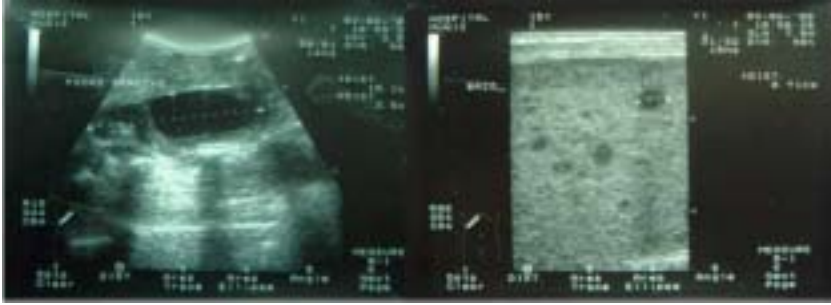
Abdominal ultrasonography showing a psoas muscle abscess and multiple hypo-echoic lesions in spleen, suggestive of TB microabscesses in the same patient as in Figure 17-7.
